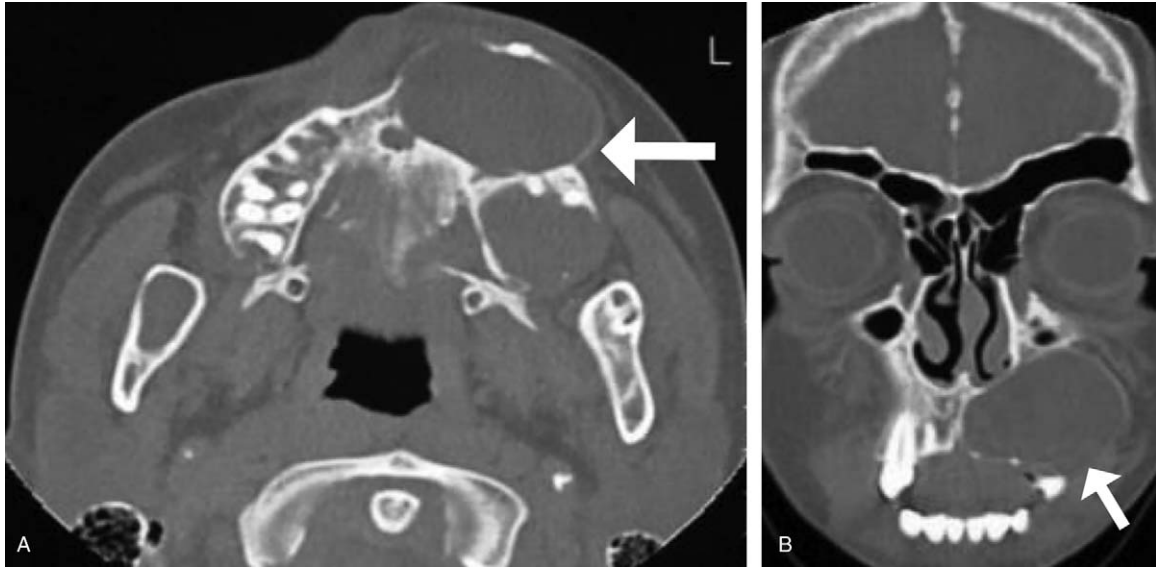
Gorlin-Goltz syndrome. Axial (A) and coronal (B) unenhanced CT images show lytic expansile lesions involving the left maxilla compatible with odontogenic keratocysts (white arrows), as well as abnormal calcification of the falx cerebri (better seen in B).
